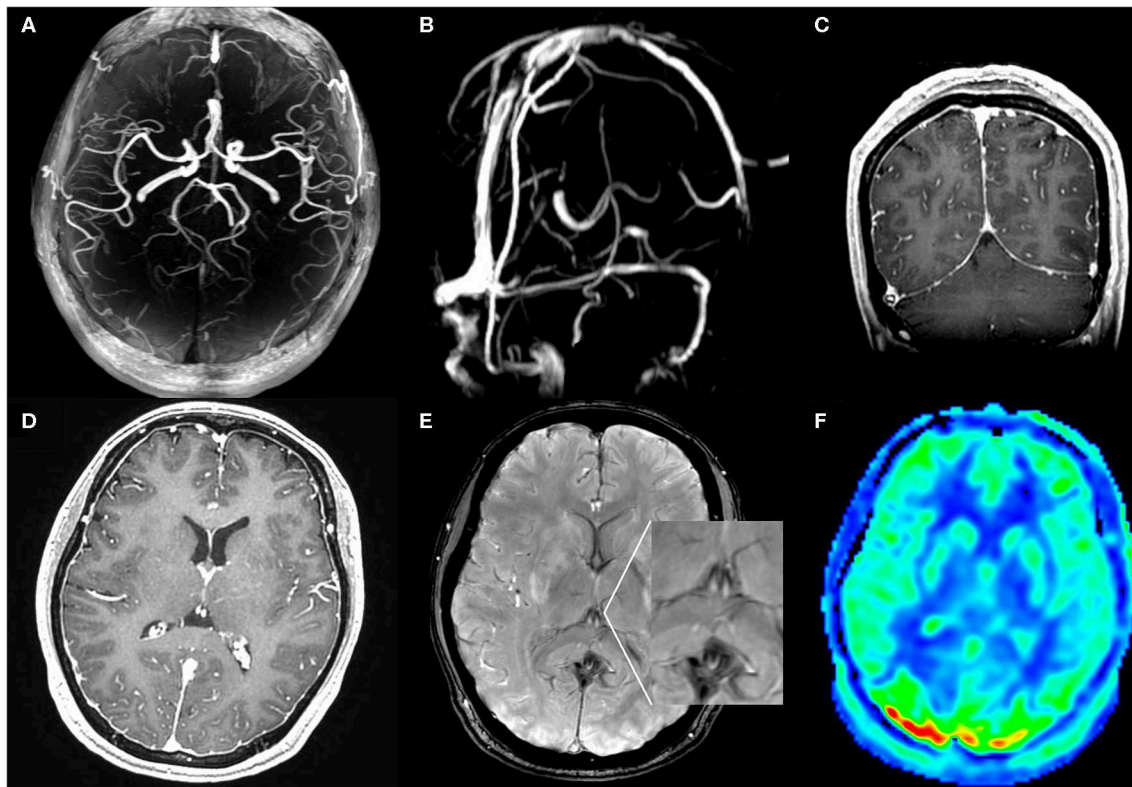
MR angiography (A), MR venography (B), post contrast T1WI (C,D), SWI (E), and ASL (F) MRI images at symptom onset: MR angiography and venography were negative for aneurysms, venous thrombosis, and cerebral vasospasm. SWI images showed lack of the normal hypointensity in deep venous system. Coronal and axial T1WI images with gadolinium-enhancement showed diffuse enhancement of the dura. ASL images showed hyperperfusion areas in bilateral occipitoparietal lobe.
